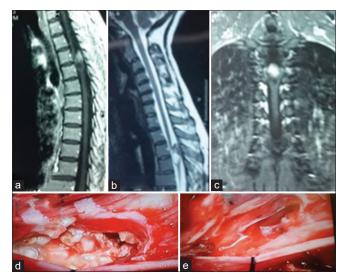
(a) Cervicothoracic T1-weighted sagittal magnetic resonance imaging (MRI) shows a mixed hypo-hyperintense mass at T3-T4 level, (b) in T2-weighted image, the mass is also hypo-hyperintense which is not usual in intramedullary epidermoid cysts, (c) but in fat-suppressed MRI the whole of the tumor is hyperintense, (d) intraoperative photograph; a milky white tumor is demonstrated after midline myelotomy, (e) after total removal of the mass.
